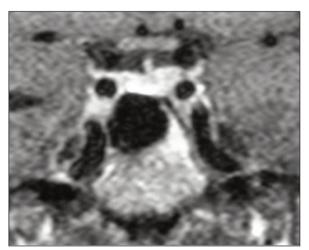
Magnetic resonance imaging findings of the case on admission and at the eighth month of cessation of antithyroid drug treatment.
